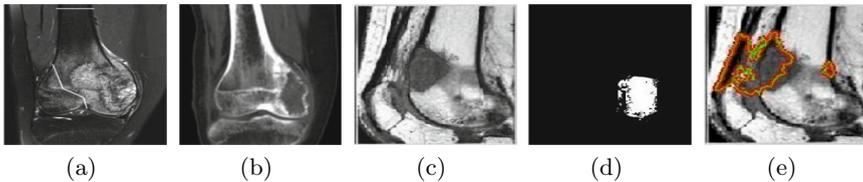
(a) T1 weighted MR image of osteosarcoma-femur, (b) CT image of osteosarcoma-femur, (c) registered image (d) initial region of the tumor region (PFCM classification result), (e) Final segmented tumor region
